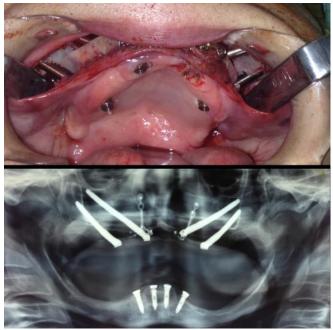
Frontal view of the atrophic maxilla post-Lefort I osteotomy fixed by two anterior plates and four ZI. Control panoramic radiography.
